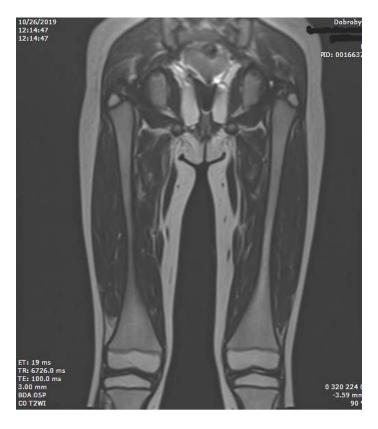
MRI of the proximal lower extremities (5-years old girl with LGMD2A) showed symmetrical atrophic changes in the major adductor muscle, the long and short adductor muscles, the semitendinosus muscle of the thigh
